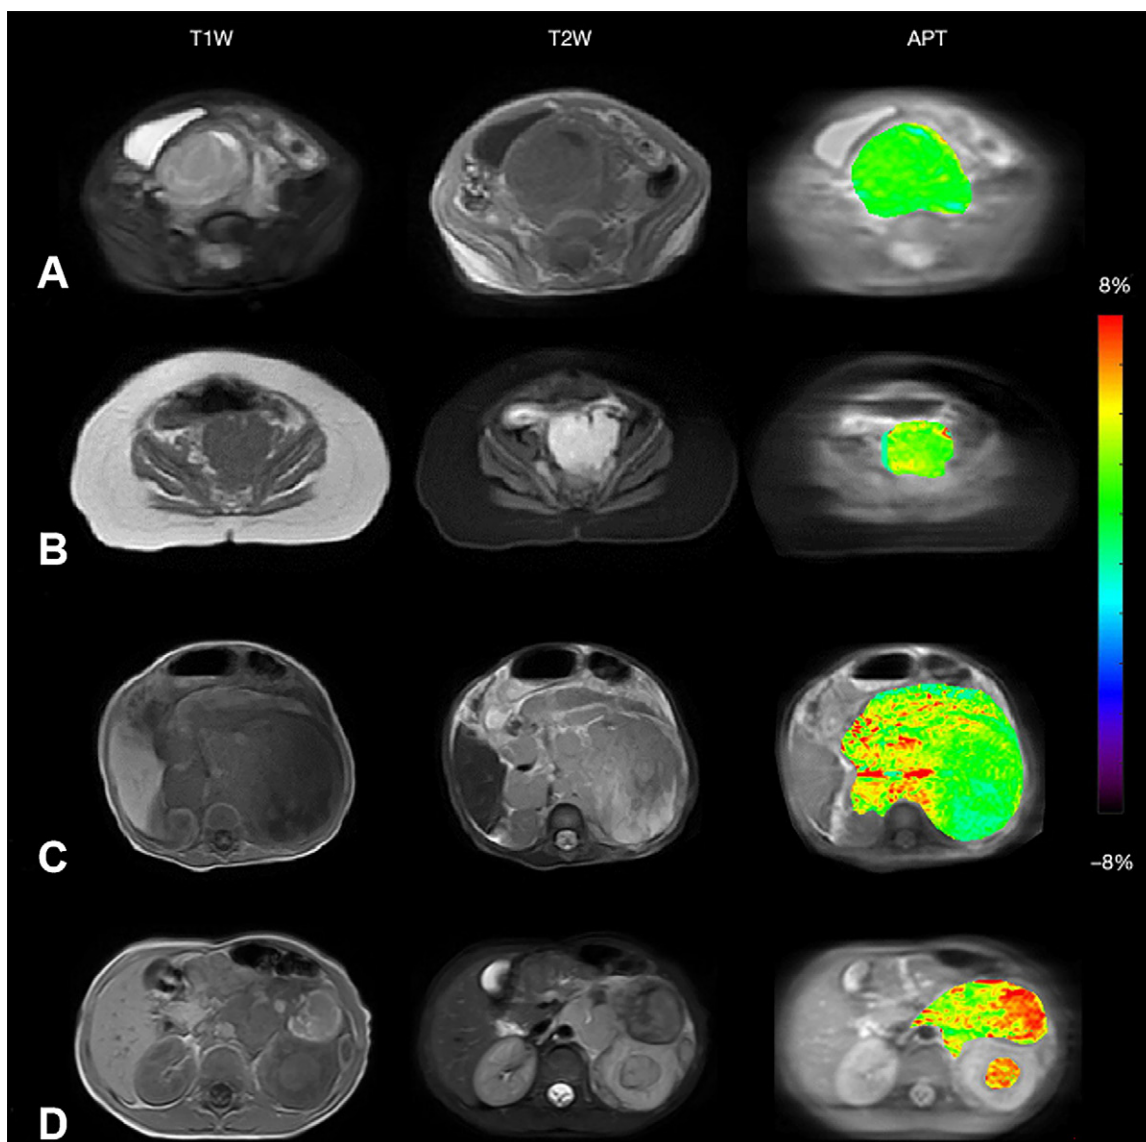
Axial T1-weighted (T1W), T2-weighted (T2W), and amide proton transfer (APT) images in patients with (A) very-low-risk, (B) low-risk, (C) intermediate-risk, and (D) high-risk neuroblastoma. (Adapted, under a CC BY-NC-ND 4.0 license, from reference 4.)
